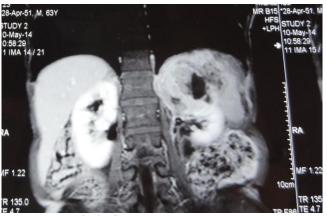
Contrast enhanced MRI
